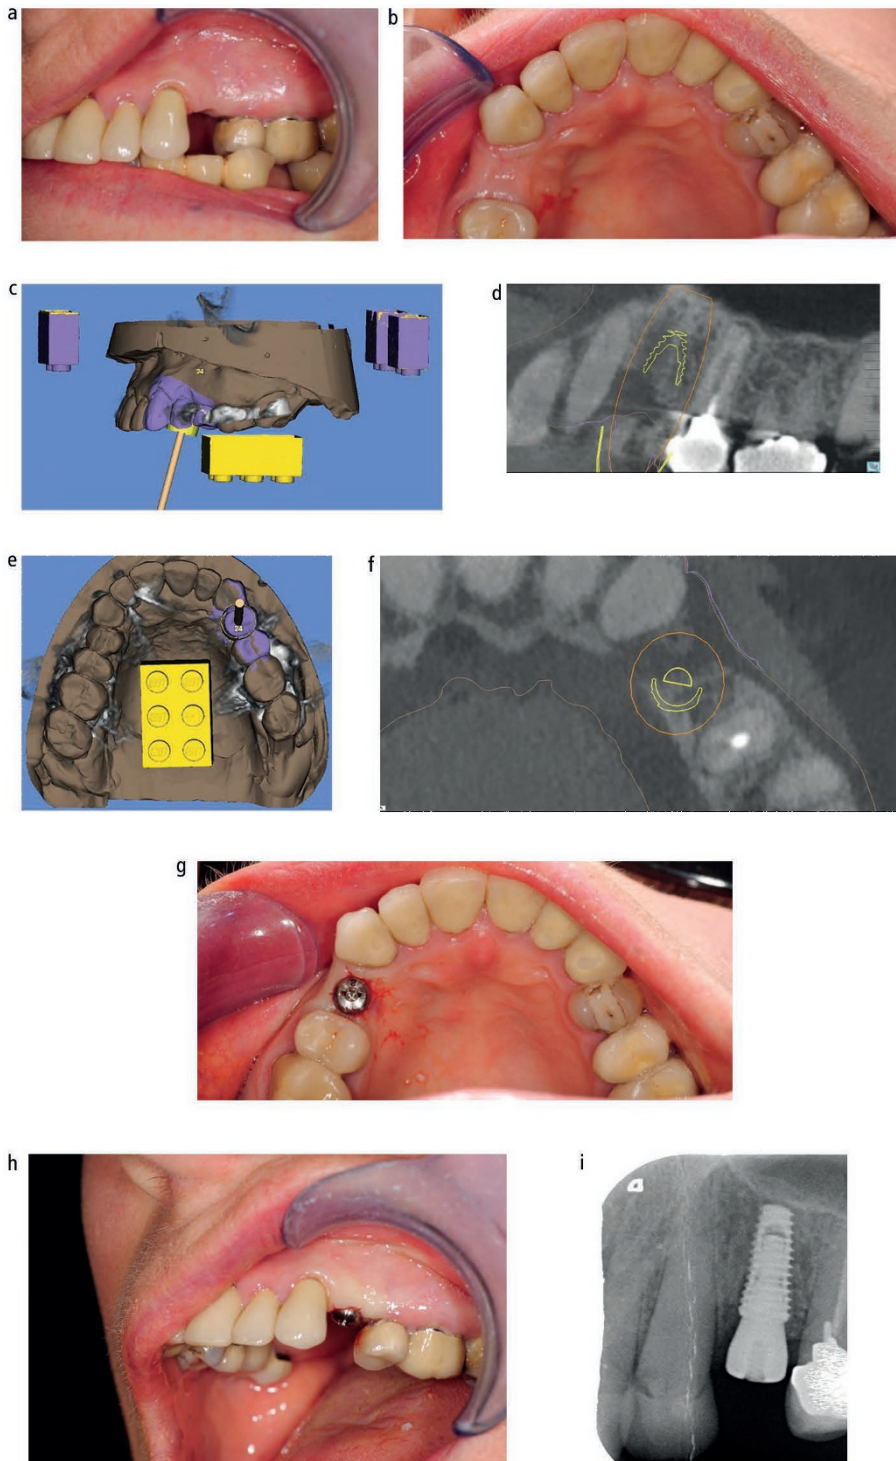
Single implant placement in the 24 site using CBCT guided flapless implant surgery (ImplantPilot system). A CBCT scan of the patient and a CBCT scan of a waxed-up study cast model have been combined as a dual scan to plan this case. (To approximate the two CBCT scans a LEGO brick has been used)
